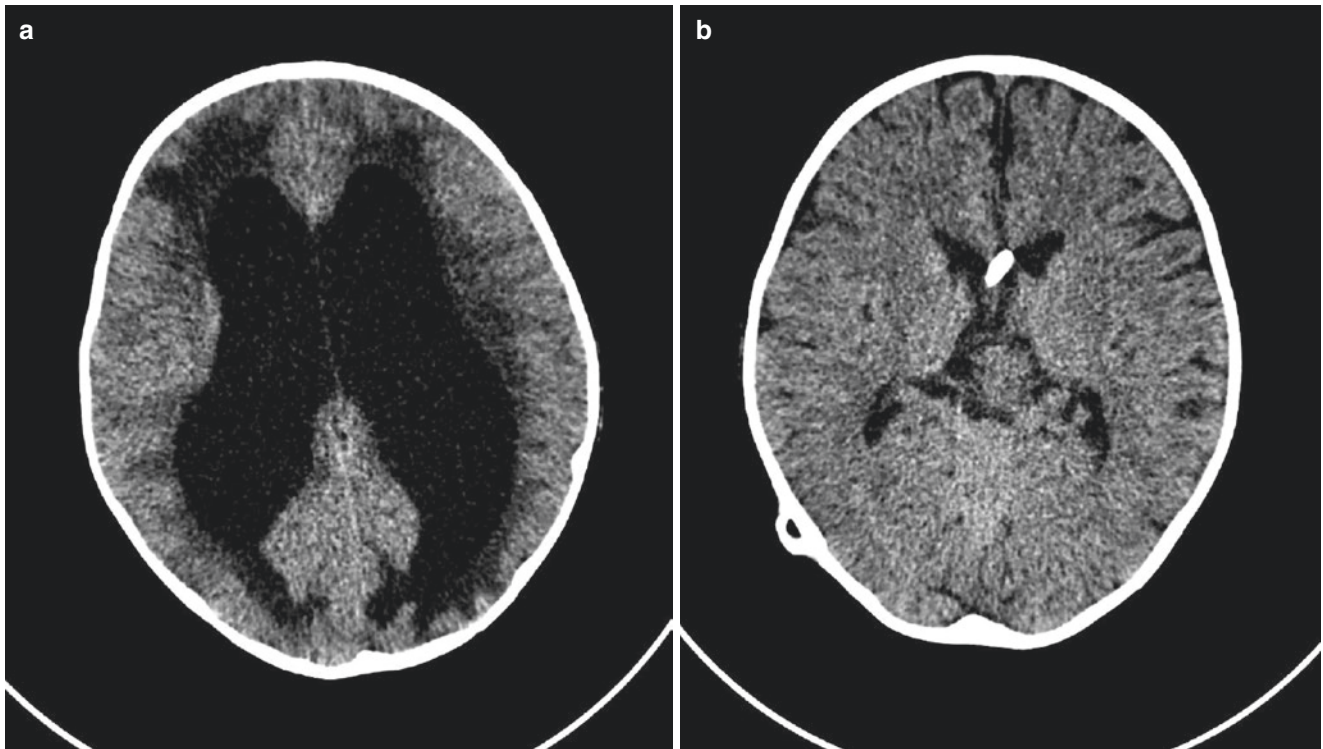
Hydrocephalus. (a) Axial CT image shows dilated lateral ventricles with adjacent transependymal oedema. (b) Following insertion of a ventriculo-peritoneal shunt, the axial CT image demonstrates decompressed ventricles with the shunt catheter in situ
